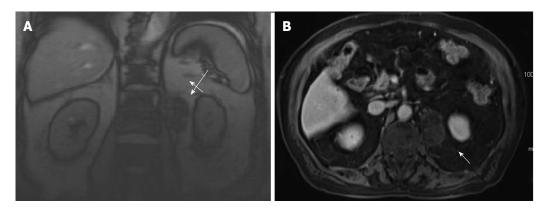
Surveillance magnetic resonance imaging. Imaging obtained 17 mo after the initial diagnostic computed tomography scan shows that the mass, located just inferior to the left renal vein (long arrow) and medial to the left kidney (arrow), increased in size to 5.0 cm × 3.4 cm in longitudinal (A) and anterior-posterior dimensions (B).
